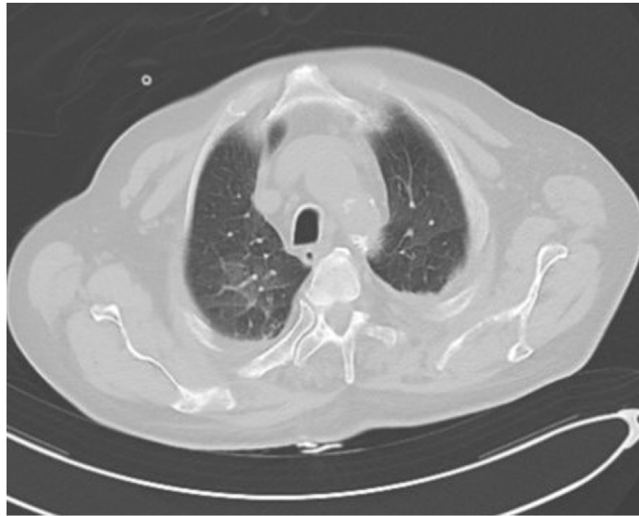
CT of Chest, Ground glass opacities and septal thickening.
